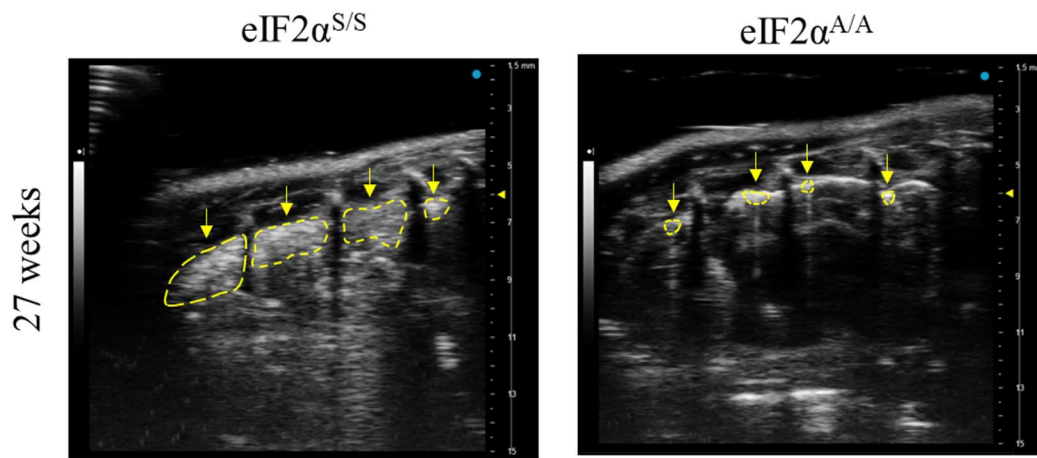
Representative ultrasound images of KRAS G12D eIF2 $\alpha^{S/S}$ and eIF2 $\alpha^{A/A}$ tumors prior to isolation of cells for scRNA-seq analysis.
